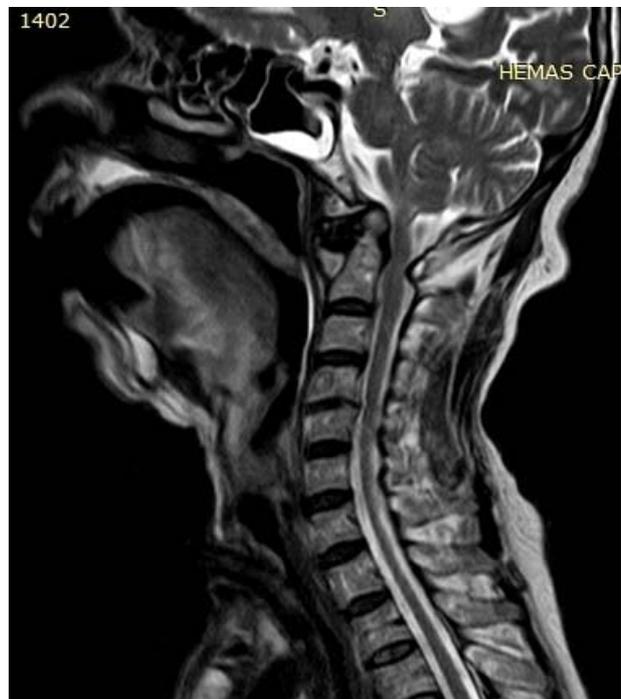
MRI (T2 weighted) of cranio vertebral region: cervical cord compression at foramen magnum.
